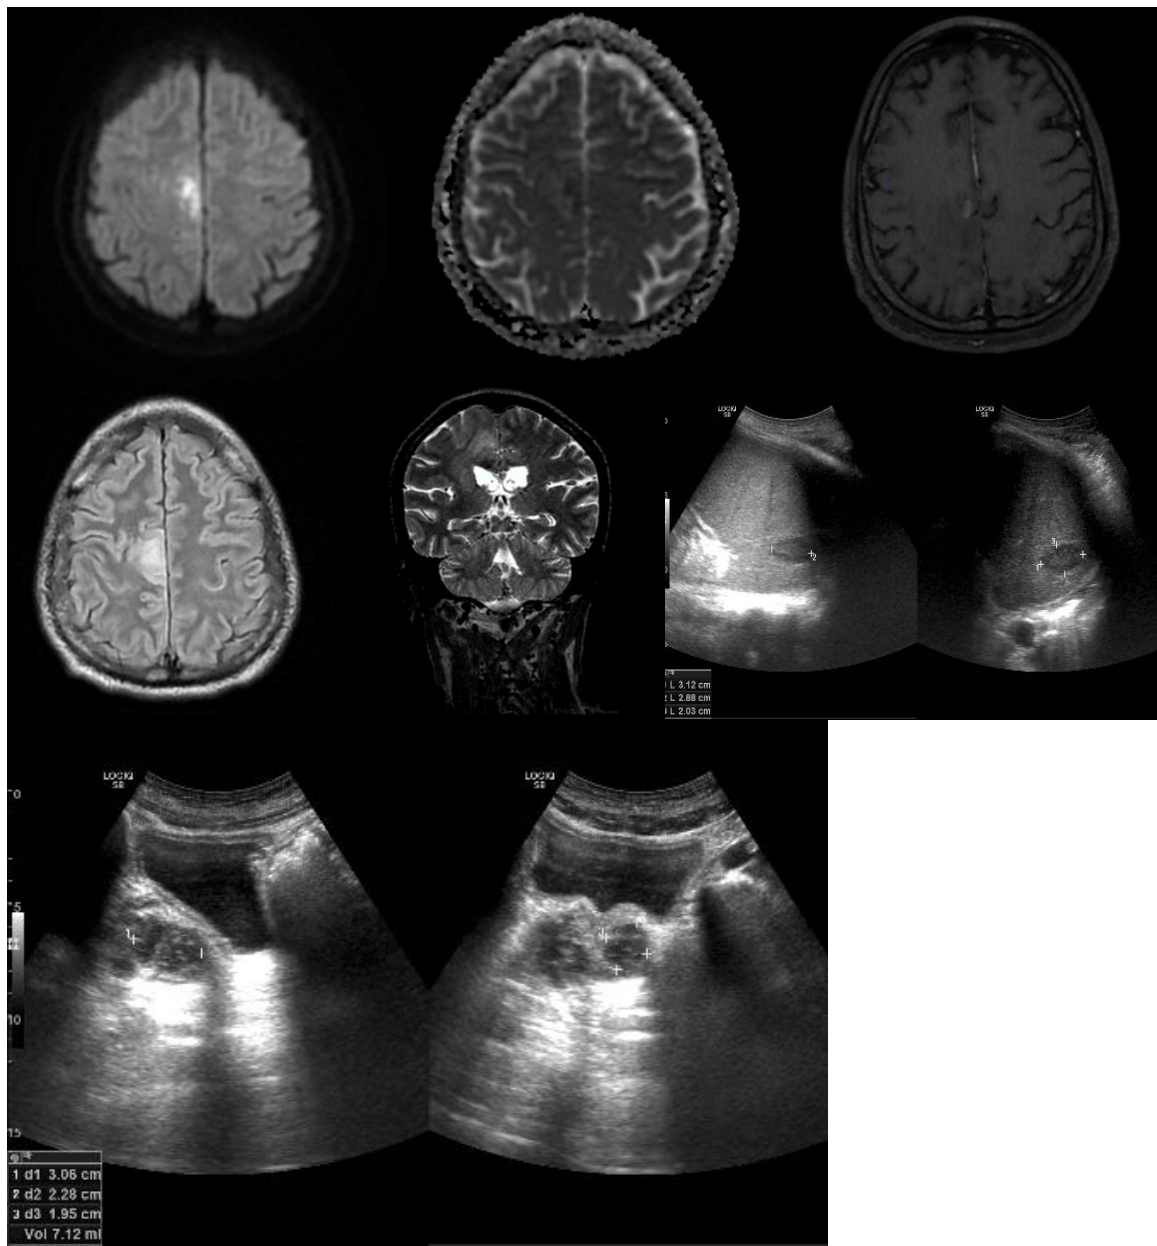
Ultrasonography of the abdomen revealed hepatosplenomegaly, prostatomegaly with abscess formation, and multiple splenic microabscesses.
